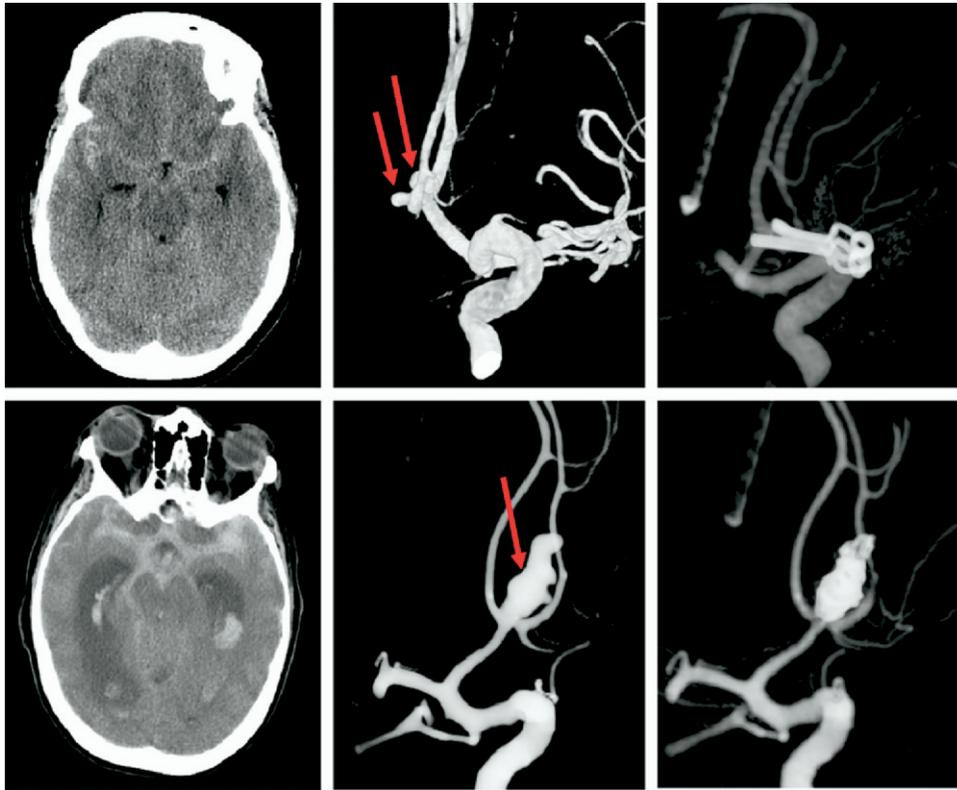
Imaging from patients with SAH. The top panel of three images shows a CT scan, 3-D angiogram showing two aneurysms (arrows) off the anterior communicating artery (one projecting to the left, the other projecting upwards, and partially obscured by the anterior communicating arteries also traveling upwards), and last, a post-operative angiogram with two clips obliterating both aneurysms. The bottom panel of three images shows similar images of another anterior communicating aneurysm that has been coiled, the third panel being an immediate post-operative study showing that the aneurysm is completely obliterated. The CT scan from the top panel is more subtly abnormal than the CT scan on the bottom panel, which shows much more blood.
